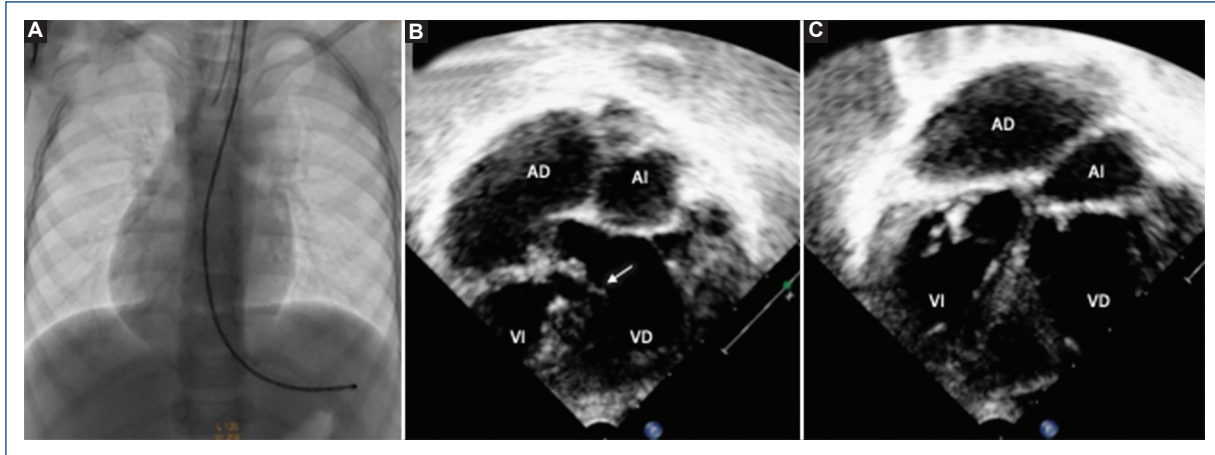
A: chest fluoroscopy: *situs solitus* in dextrocardia. B and C: transthoracic echocardiogram (apical 4-chambers view): straddling (arrow) of right AV valve (mitral) and anatomical right ventricle (RV) at the left side (dropped trabeculation and moderated band).
